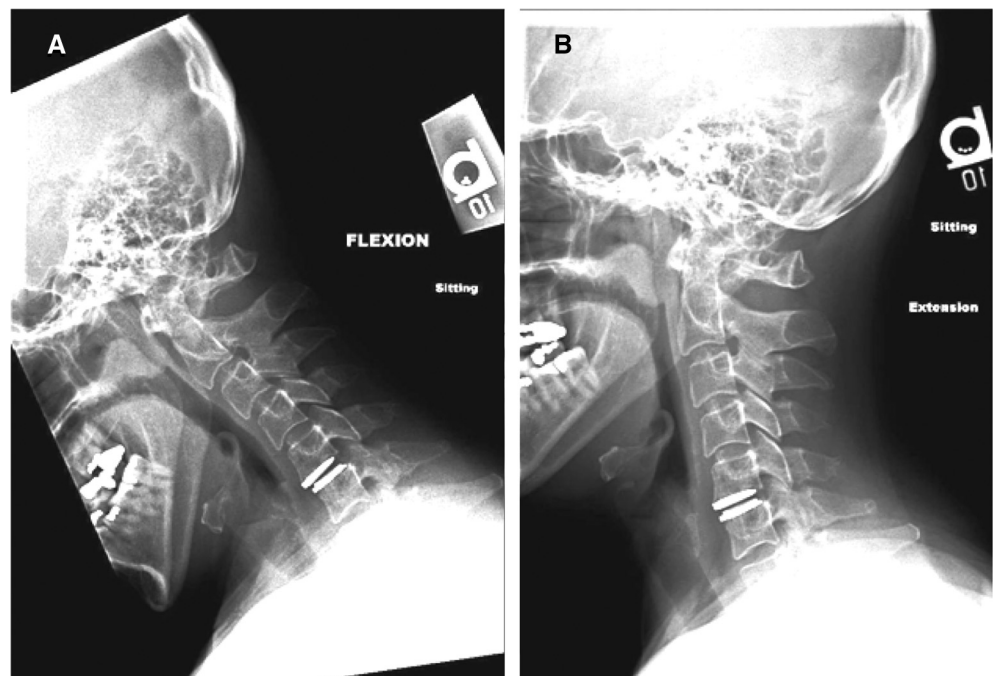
Postoperative lateral flexion (A) and extension (B) C-spine x-rays of the same patient as in Figure 5 at the 1-year follow-up demonstrating good preservation of cervical motion.
